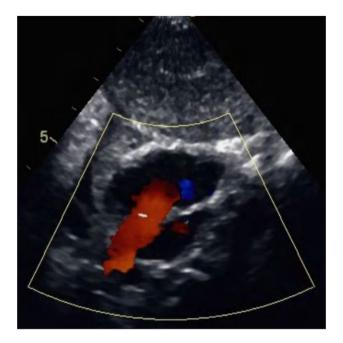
The two-dimensional color Doppler echocardiography presented that the blood flow through the superior vena cava can smoothly pass through the atrial defect
